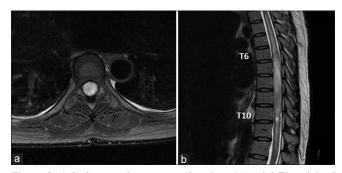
Spinal magnetic resonance imaging. (a) Axial T1-weighted gadolinium-enhanced with fat suppression images showing high intensity and swollen spinal cord lesion with loss of subarachnoid space. (b) Swollen spinal cord from the 6th to 10th thoracic spine levels
